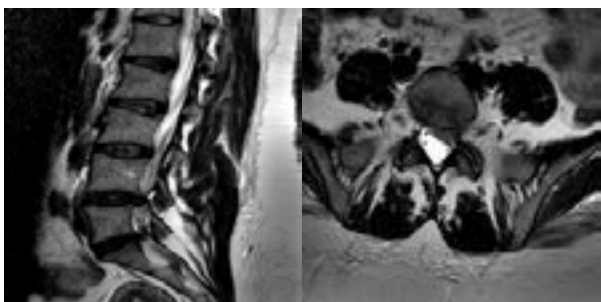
MRI lumbar spine T2 sagittal and axial view of a female patient has lower back pain and left sciatic pain shows: L5/S1 level left mediolateral disc protrusion, indenting the thecal sac and severely compromising the left exiting neural foramina.
